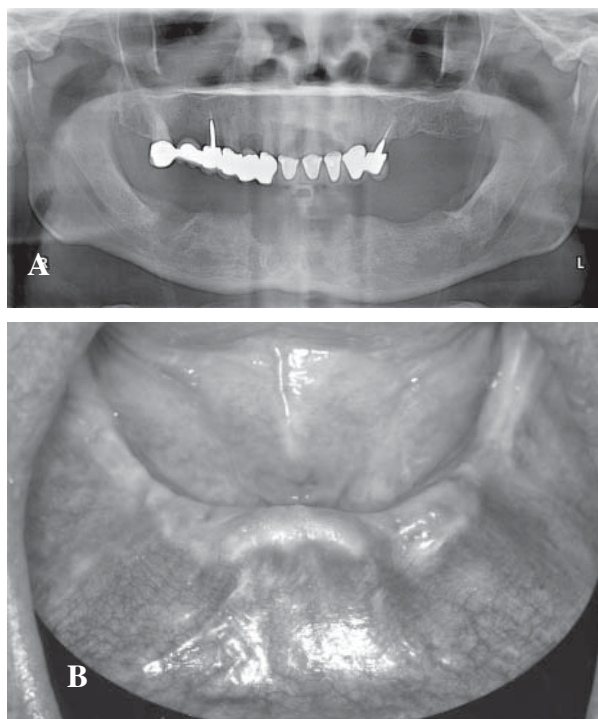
Preoperative condition of a 48-year-old male with multiple extractions in the mandible by another practitioner. A. Preoperative panoramic radiograph. Note the irregularities in the contours of the lower ridge, B. Preoperative ridge.
